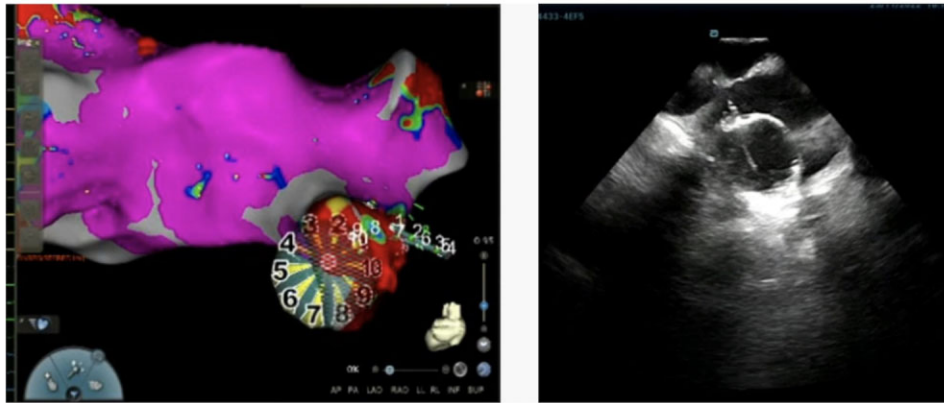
Left:* Heliostar[®] radiofrequency balloon displayed on Carto 3[®] navigation system, showing its 10 electrodes. *Right:* intracardiac ultrasound image showing the sheath crossing the interatrial septum and the Heliostar balloon lodged in a pulmonary vein.
